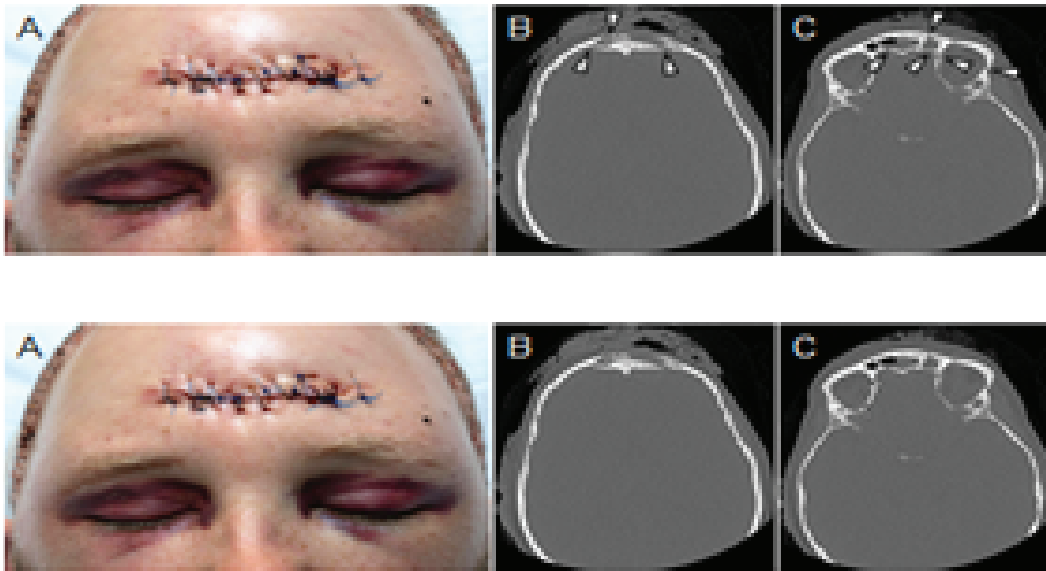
A) Photograph demonstrating the patient's bilateral periorbital ecchymosis or "raccoon eyes"; B) Non-contrast head CT (axial view) demonstrating heavily comminuted and depressed frontal calvarial fracture with communication between the central nervous system and skin; C) Non-contrast head CT (axial view) demonstrating fractures involving the medial and lateral wall of the left orbit as well as through the anterior and posterior walls of the frontal sinuses.
